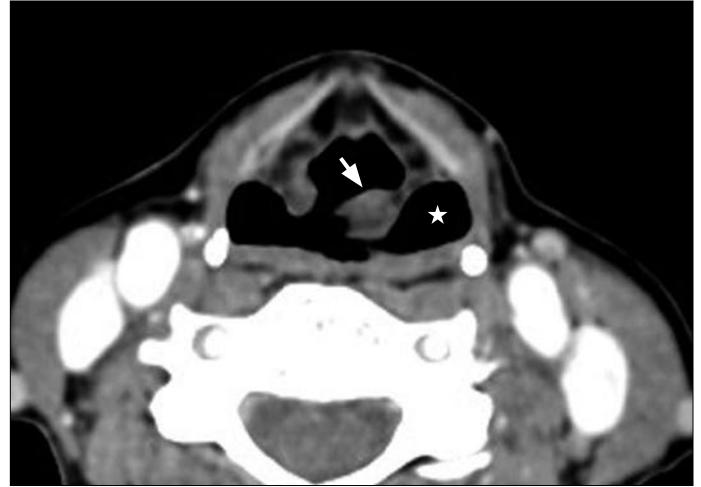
Axial CT image through the superior larynx reveals an anteromedial rotation of the left aryepiglottic fold (arrow) with resultant mild dilatation of the left pyriform sinus (star).
